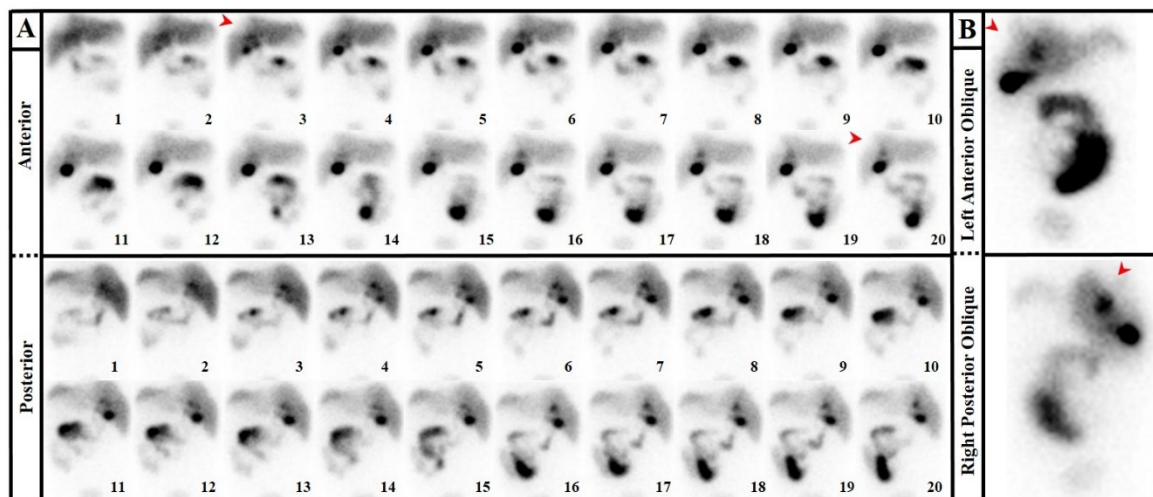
Dynamic hepatobiliary scintigraphy performed over 60 minutes following intravenous administration of 55 MBq of [^{99m}Tc]Tc-BrIDA. (Panel A) Final 20 minutes of the dynamic acquisition demonstrate gradual tracer accumulation in segment V of the liver, with a photopenic area identified in the right upper quadrant beneath the diaphragmatic surface (arrowheads). The photopenic region is less conspicuous on the posterior dynamic view, likely due to overlapping activity from segment VII. (Panel B) Static images obtained in the left anterior oblique and right posterior oblique projections confirm the presence of the photopenic area (arrowheads), improving lesion conspicuity and raising suspicion for a biloma
